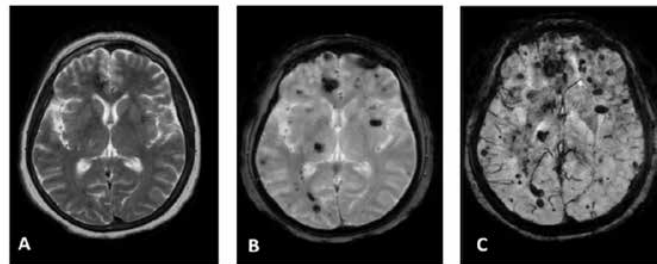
A, Axial T2-weighted image shows three foci of low signal intensity on the right frontal, occipital and left basal ganglia regions. B, T2*-weighted GRE image demonstrates multiple foci of low signal intensity on the both cerebral hemisphere regions (type IV). C, SWI shows a higher number of lesions and confirms the presence of larger lesions, which are not seen on the T2*-weighted GRE image
